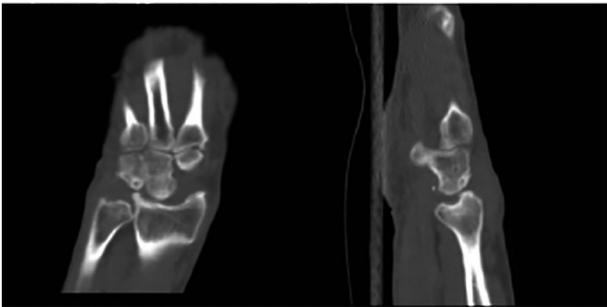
CT images of the impingement site clearly show subchondral cyst formation in the hamate
